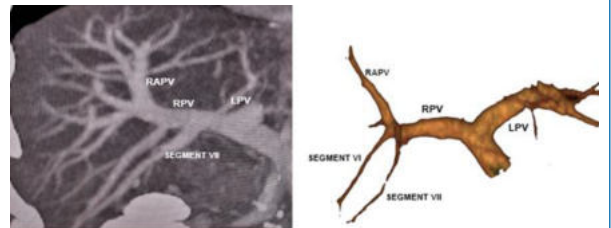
CT axial reformatted MIP and VR images in the portal venous phase showing the separate origin of right posterior segment VII branches (TYPE IV) from the right portal vein
